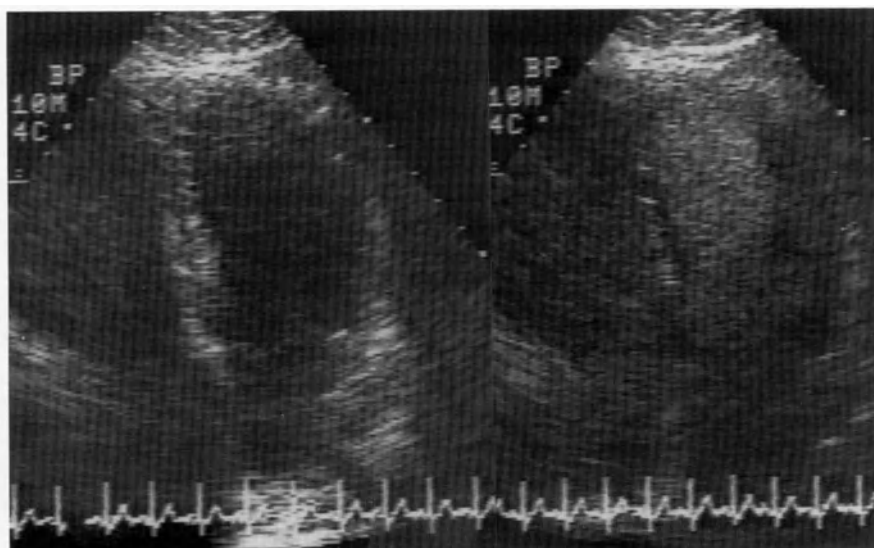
Apical four chamber view in an individual undergoing pharmacologic stress echocardiography. The blood pool has been opacified and the endocardial borders subsequently enhanced following an injection of intravenous sonicated Albumin solution.
